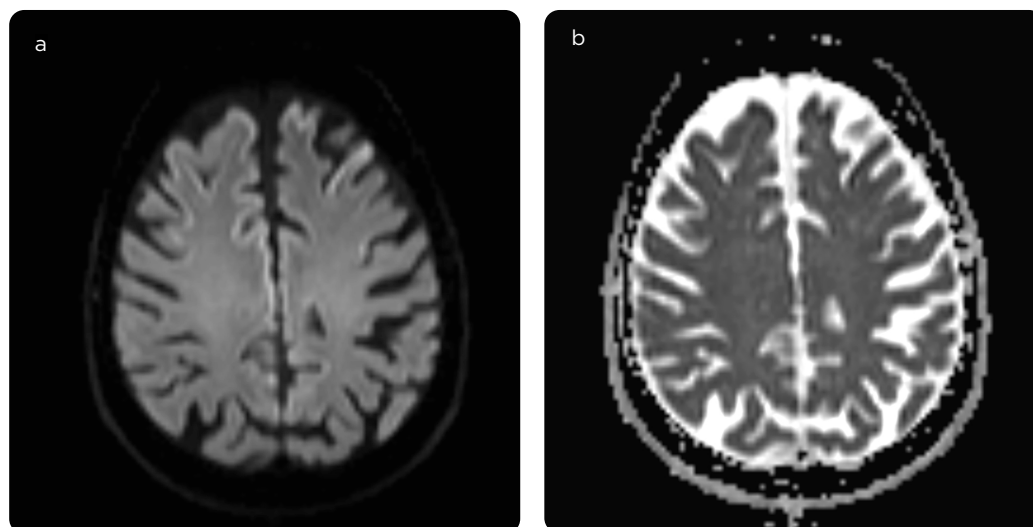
Brain MRI in diffusion sequences (b1000 coefficient) and ADC, axial. a) Areas of diffusion restriction visualized as high signal in the bilateral frontal cortex of left predominance, and in the cortex of the cingulate gyrus and b) corresponding to areas of low signal in the ADC map.
